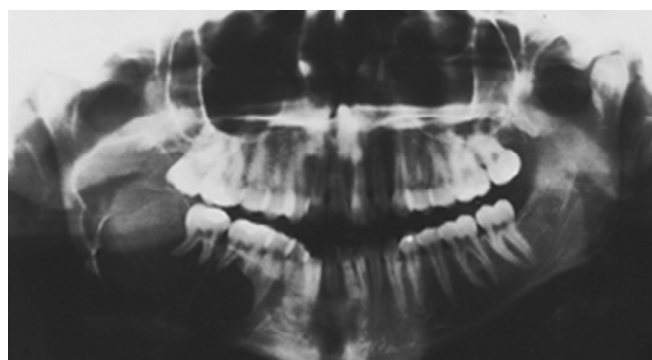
Radiographic picture of dentin dysplasia showing almost complete obliteration of the pulp chamber
